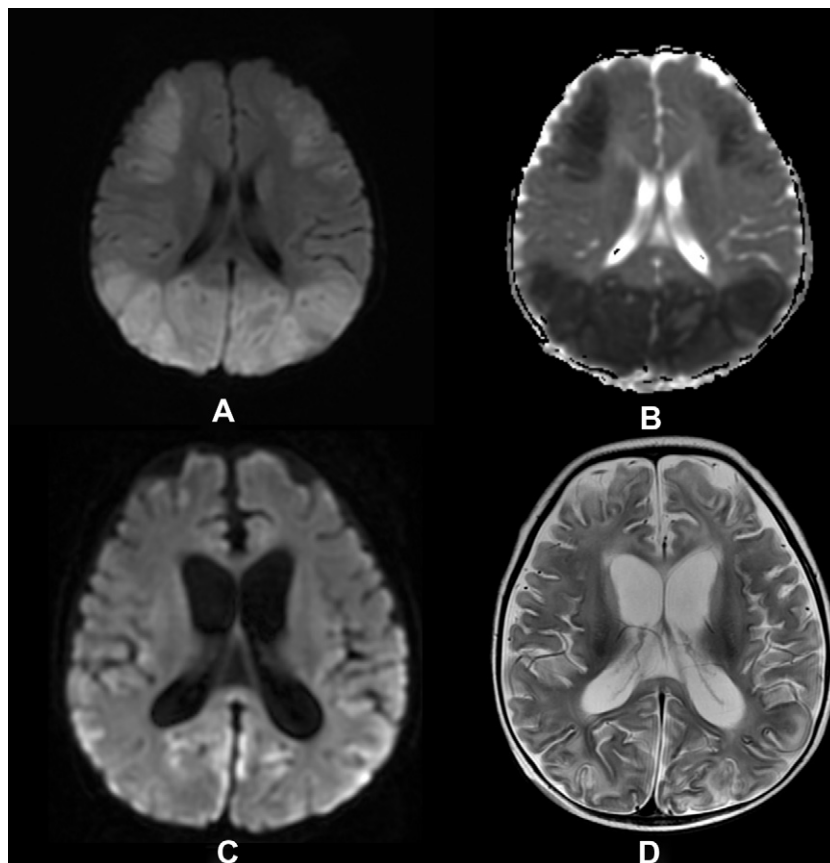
(A) Axial DWI at the second day of illness. There are abnormal high intensity areas in the bilateral caudate, frontal lobes, predominantly occipital lobes. (B) Axial ADC maps on the second day of illness. The corresponding lesion (bilateral caudate, frontal lobes, predominantly occipital lobes) had decreased ADC values. (C) Axial DWI on the 22nd day of illness. The abnormal high intensity areas largely disappeared. (D) Axial FLAIR on the 22nd day of illness. Prominent ventricles are evident, and diffuse brain atrophy is evident.
